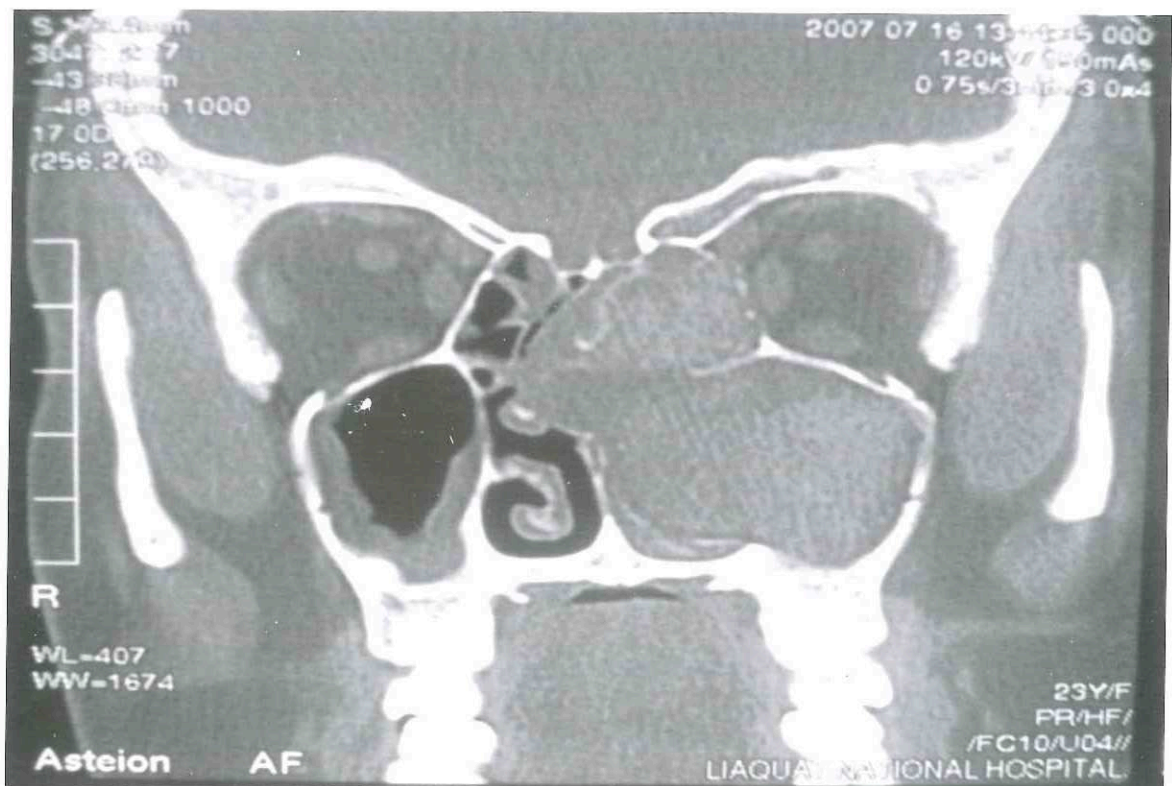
CT scan of Paranasal sinus.
